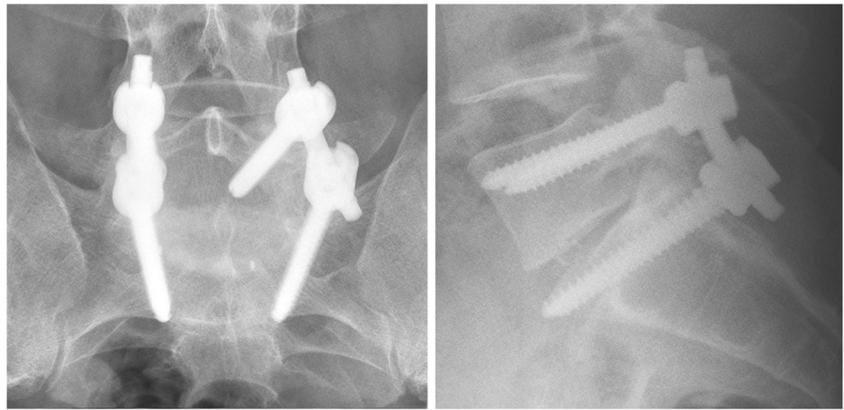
X-ray images at 6 months after surgery
